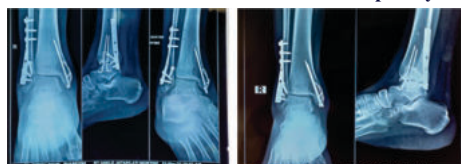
Three Months And Eight Months Follow Up Xray
